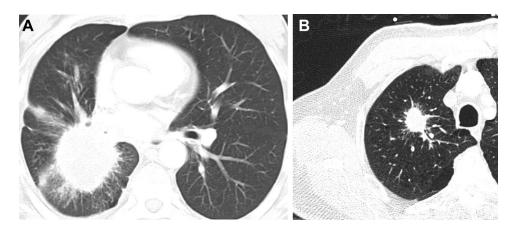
A, CT chest scan showing the corona radiata sign in a patient with non-small cell lung cancer. B, CT chest scan showing the corona radiata or sunburst sign in a patient with moderately differentiated squamous cell carcinoma.
